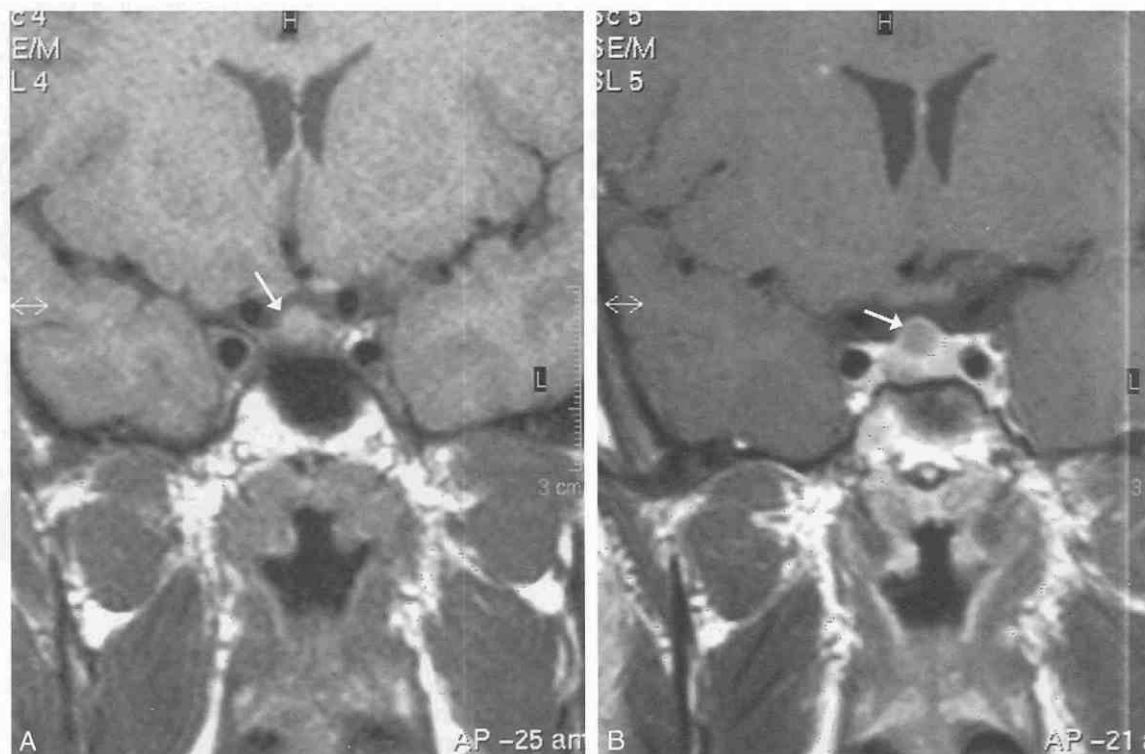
Prolactin secreting pituitary microadenoma. A, Coronal T1-weighted thin section MR image through the midsella demonstrates a round isointense mass arising from the right side of the pituitary gland and projecting upward into the suprasellar cistern (arrow). B, Coronal T1-weighted image obtained shortly following intravenous gadolinium administration. Normal pituitary tissue demonstrates homogeneous contrast enhancement, while the round mass shows little or no enhancement.
